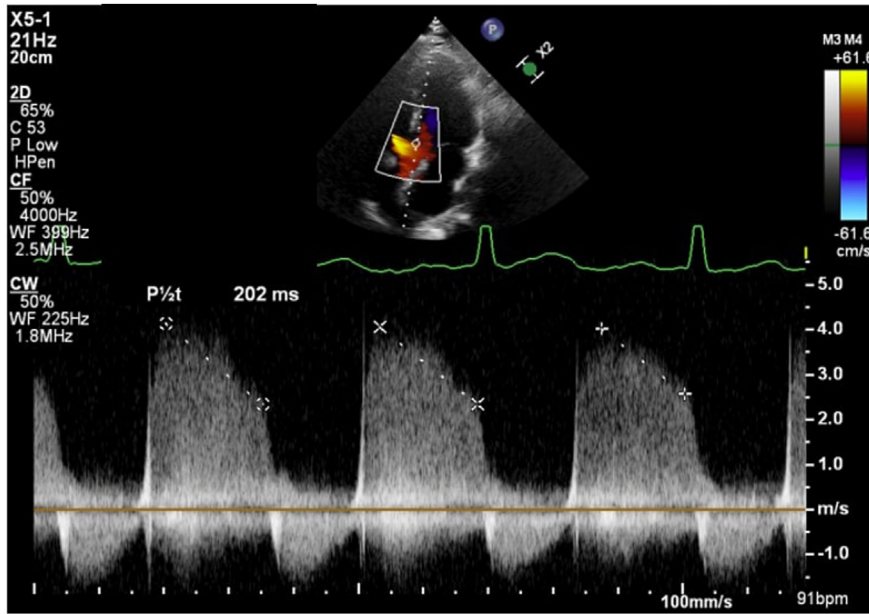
Two-dimensional TTE, apical 5-chamber view, pulsed-wave Doppler through the aortic valve, demonstrates a pressure half-time (P1/2t) of ~200 msec, suggesting severe AR.
